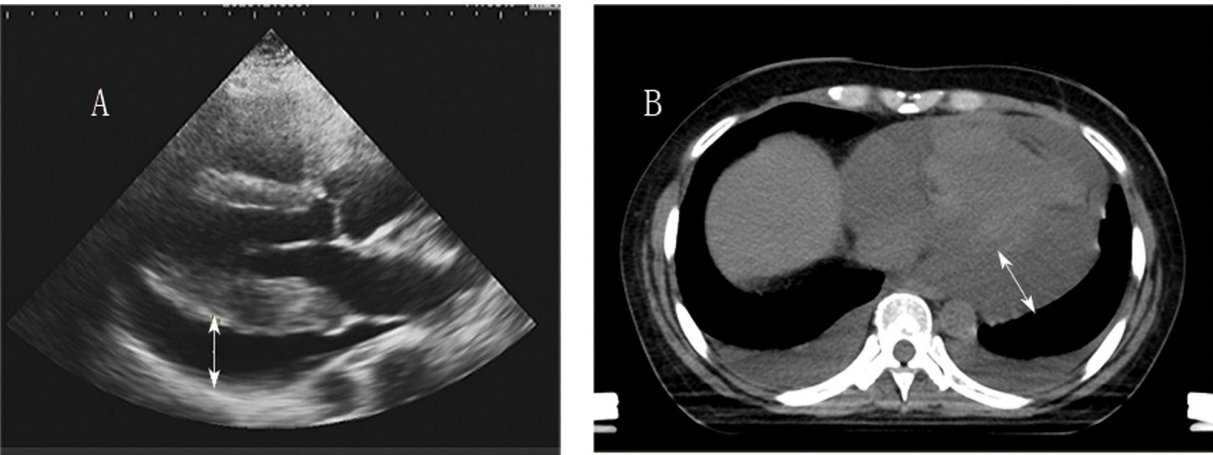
Pericardial effusion. (A) Echocardiography prior to radiotherapy indicated pericardial effusion (arrow) (December 2020). (B) Chest CT before radiotherapy revealed pericardial and bilateral thoracic low-density fluid, i.e., pericardial effusion (arrow) (December 2020).
